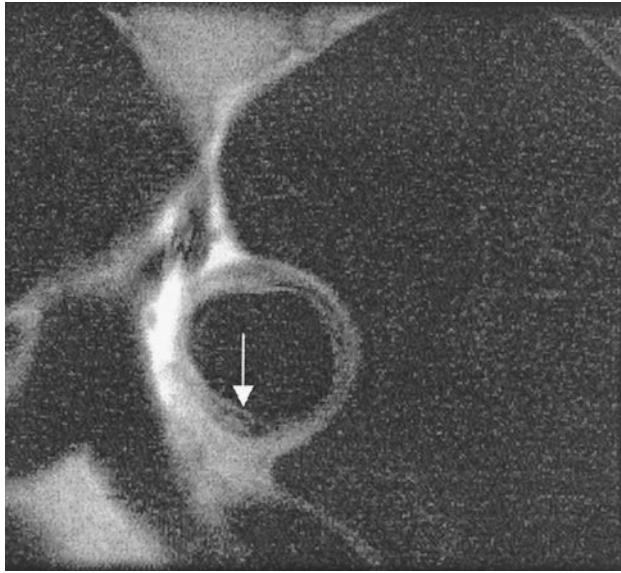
Transesophageal MRI of the distal aortic arch of a 77-year-old male with remote stroke, showing heterogeneous atherosclerotic thickening and intraplaque calcification or hemorrhage (arrow). Reprinted with permission from The American College of Cardiology (*J Am Coll Cardiol* 2001;37:2031–5).
